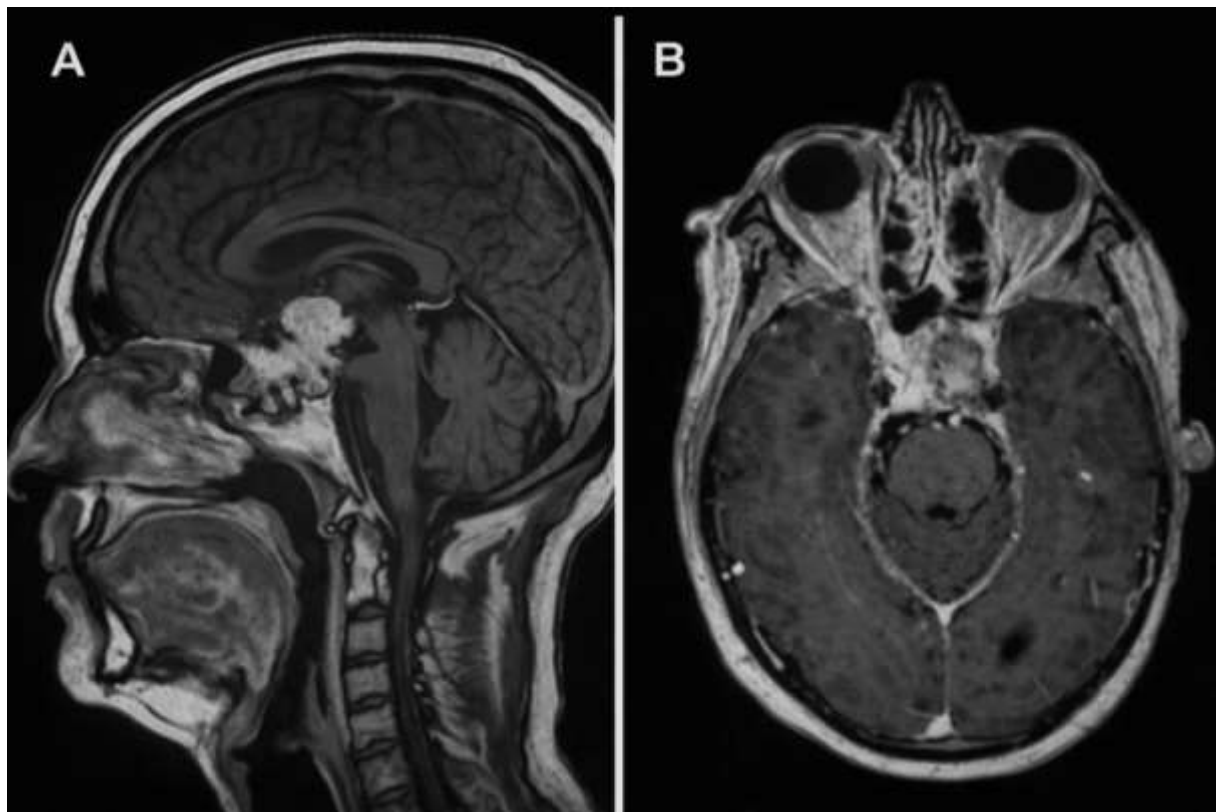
Hypothalamic–pituitary MRI showing an invasive macroprolactinoma, classified as Knosp grade 3a, measuring 30 × 28 × 44 mm in diameter.
